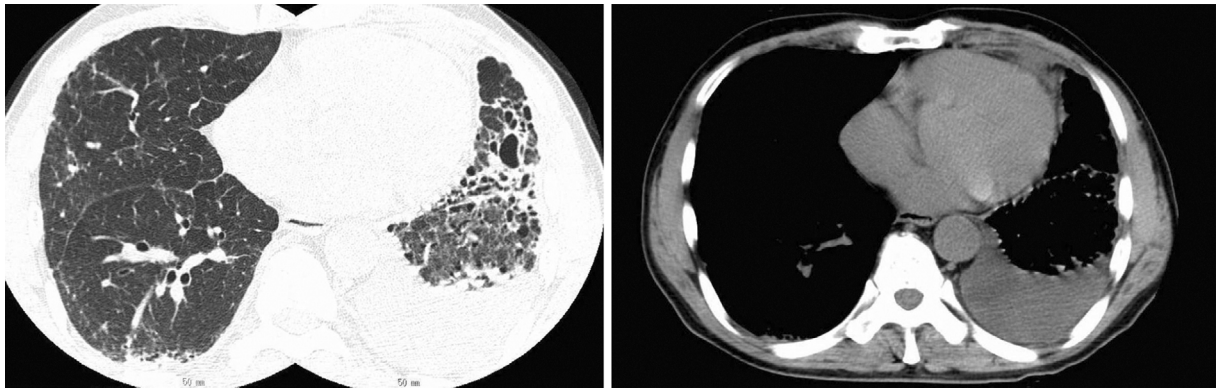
Chest CT on admission (7 weeks after starting pirfenidone) showing left pleural effusion, reticular opacities with traction bronchiectasis and honeycombing in the lower lobes. The CT images were spliced for display purposes.
